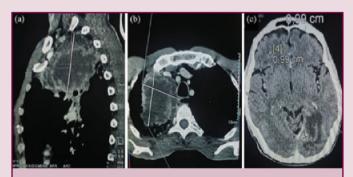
Sagittal (a) and axial (b) views of contrast-enhanced thoracic computed tomography (CT) revealing a massive tumor mass in the apicodorsal region of the right upper lobe of the lung. Axial (c) view of contrastenhanced cerebral CT revealing a well-defined, homogeneous process that avidly enhances, surrounded by a prelesional hypodensity zone, in direct contact with the left side of the cerebellar tent (red arrow).
